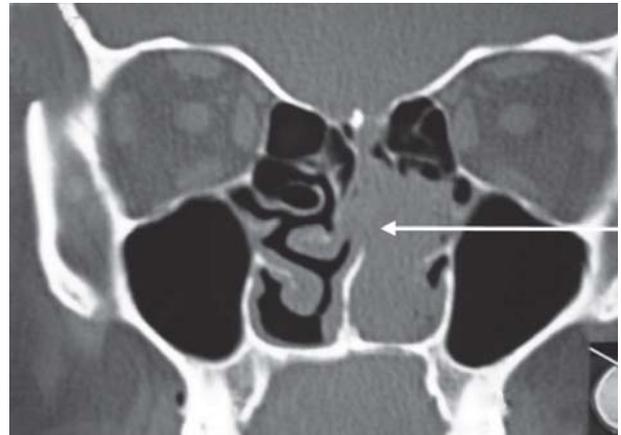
CT-PNS coronal section showing the mass
